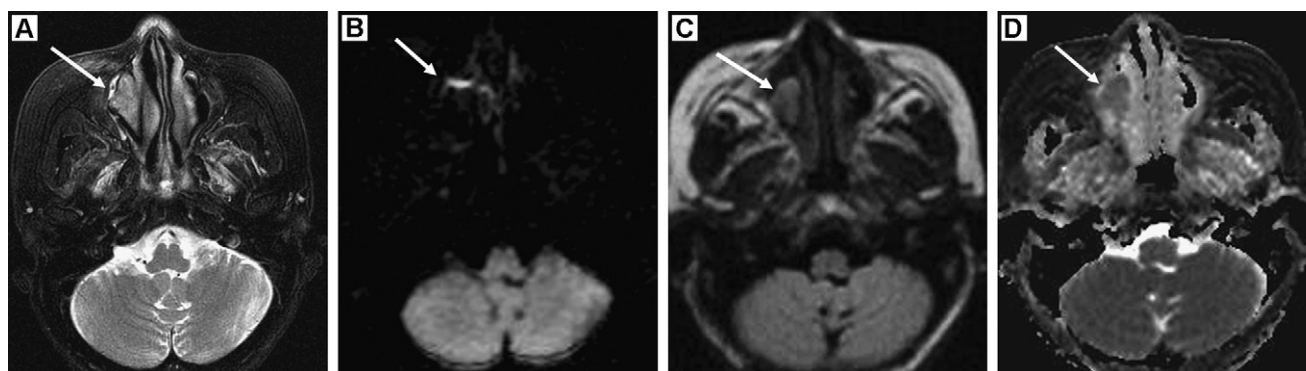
In a 64-year-old woman with malignant melanoma: A: T2-weighted fat-suppression image shows a tumor in the right maxillary sinus (arrow); B: echoplanar DWI ($b = 1000\text{ s/mm}^2$) shows a prominent susceptibility artifact (arrow), resulting in image degradation; C: line-scan DWI ($b = 1000\text{ s/mm}^2$) reveals the tumor without susceptibility artifacts (arrow); D: the ADC map shows values within the tumor (arrow) to be lower (mean: $0.98 \times 10^{-3}\text{ mm}^2/\text{s}$) than those of adjacent structures.
